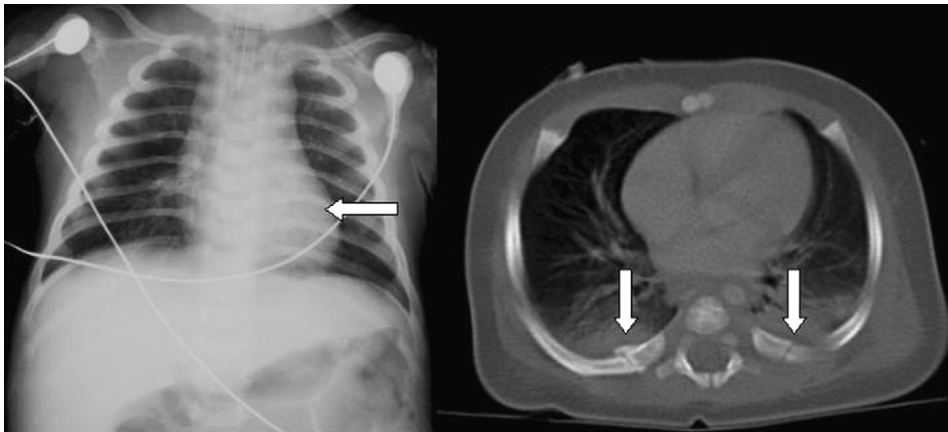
Bilateral posterior rib fractures seen by CT, while only unilateral left 7th rib posterior fracture was detected by CXR.
